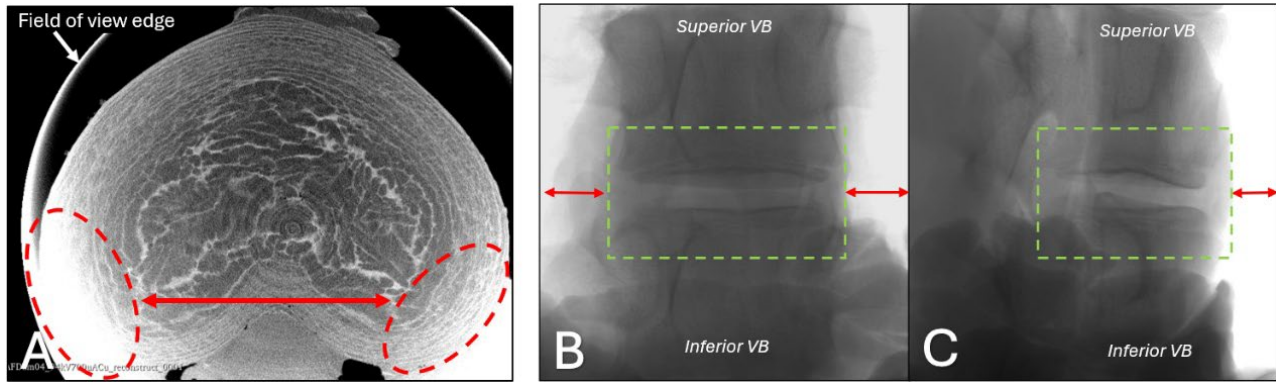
(A) Overexposed outer edges of the disc in Test 6 due to positioning the FSU too closely to the detector. (B) Frontal and (C) sagittal x-ray views of the FSU pre-scan showing the recommended 7–10 mm margin (red arrows) between the ROI and edge of the frame.
